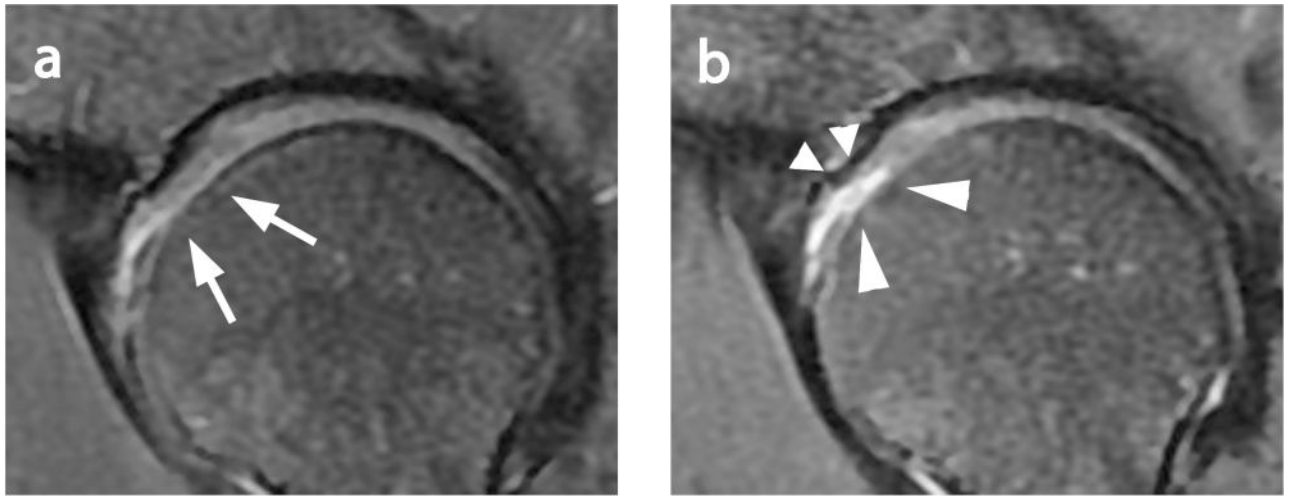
Sagittal intermediate-weighted MR images demonstrate progression of cartilage loss: at baseline (a) anterior femoral cartilage partial-thickness lesion (arrows) and at 18 month-follow-up (b) full-thickness cartilage lesion at the same site (long arrowheads). Opposing anterior acetabular cartilage that was intact on baseline shows new partial thickness cartilage lesion (short arrowheads) at follow up.
